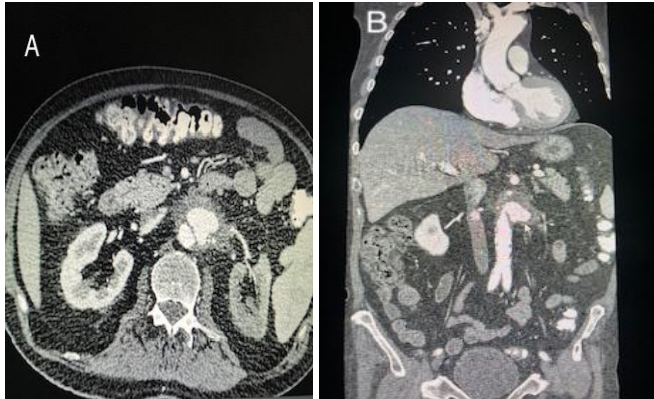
(Panel A / Panel B) - Abdominal CT-angiography showed aneurysmal dilatation in sections passing through the abdominal aorta at the level of the renal artery
